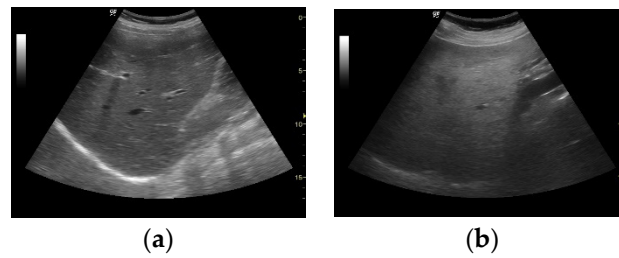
An acquired image from an ultrasound scan machine (a) normal liver and (b) fatty liver.
